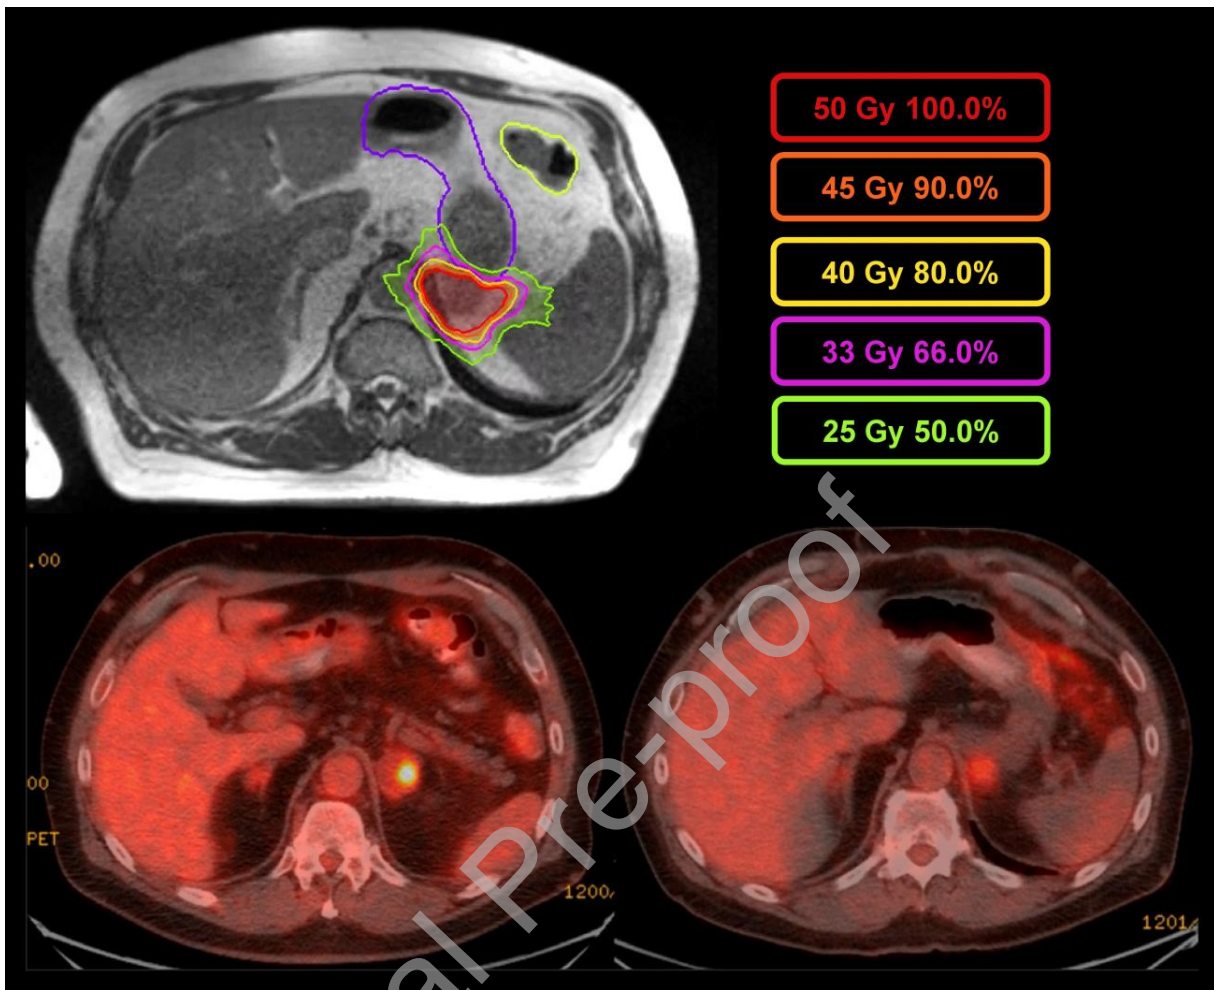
Top: SBRT treatment plan with isodose lines. The PTV was 80.6 cm<sup>3</sup>, created by adding a 5 mm margin to the 23.1 cm<sup>3</sup> GTV. The colon and stomach are highlighted in purple and yellow. Bottom left: FDG-PET prior to SBRT. Bottom right: FDG-PET at 3 months after SBRT, demonstrating metabolic treatment response.
